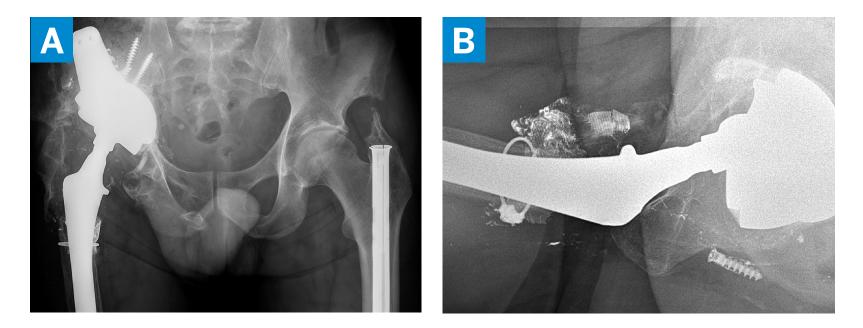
Postoperative right hip radiographs: A) antero posterior view; B) cross-table lateral view.
